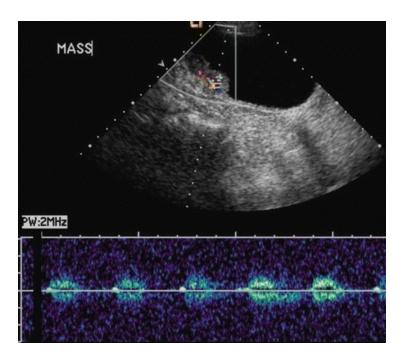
Ultrasound d emonstrates a urothelial carcinoma mass near the right ureteral orifice with internal blood flow
